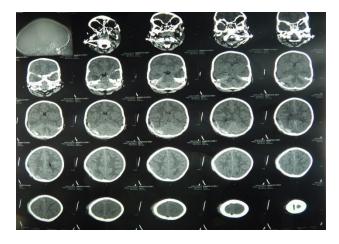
(A): Preoperative CT scan brain of case1.
